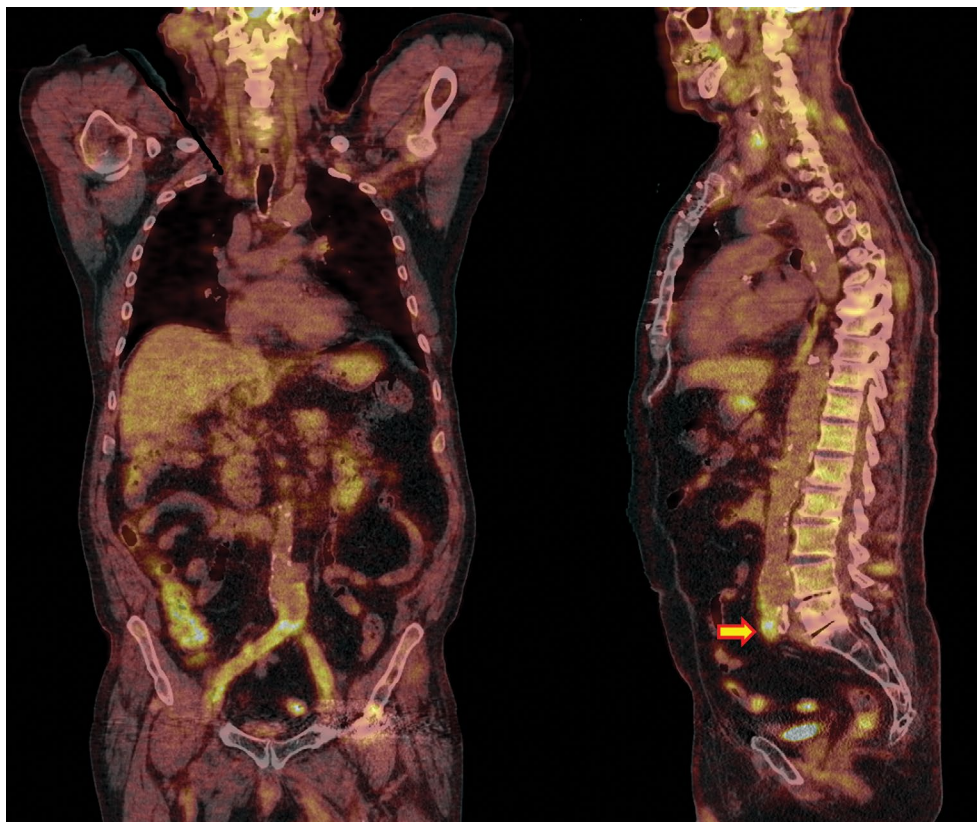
Focal ^{18}F -FDG uptake (arrow) in infected classical prosthesis displayed on coronal and sagittal projections of ^{18}F -FDG PET/CT
